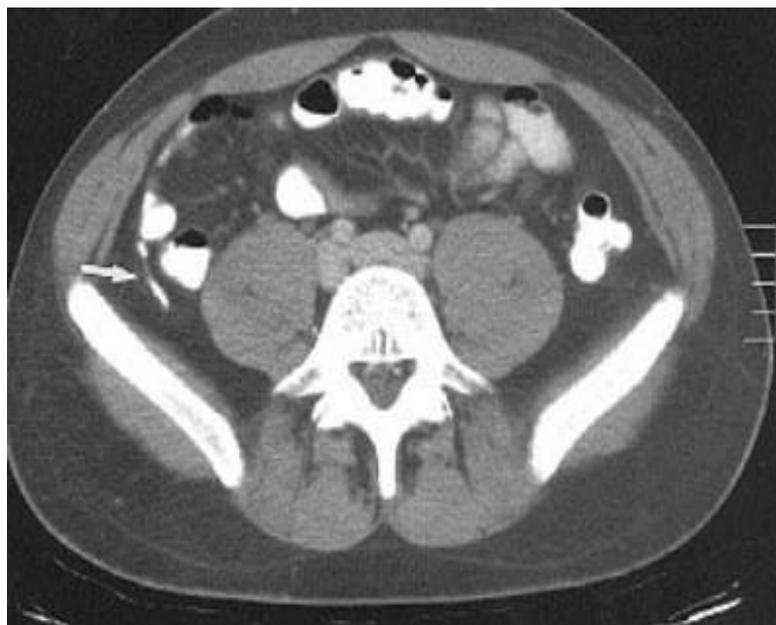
Appendix axial CT image
